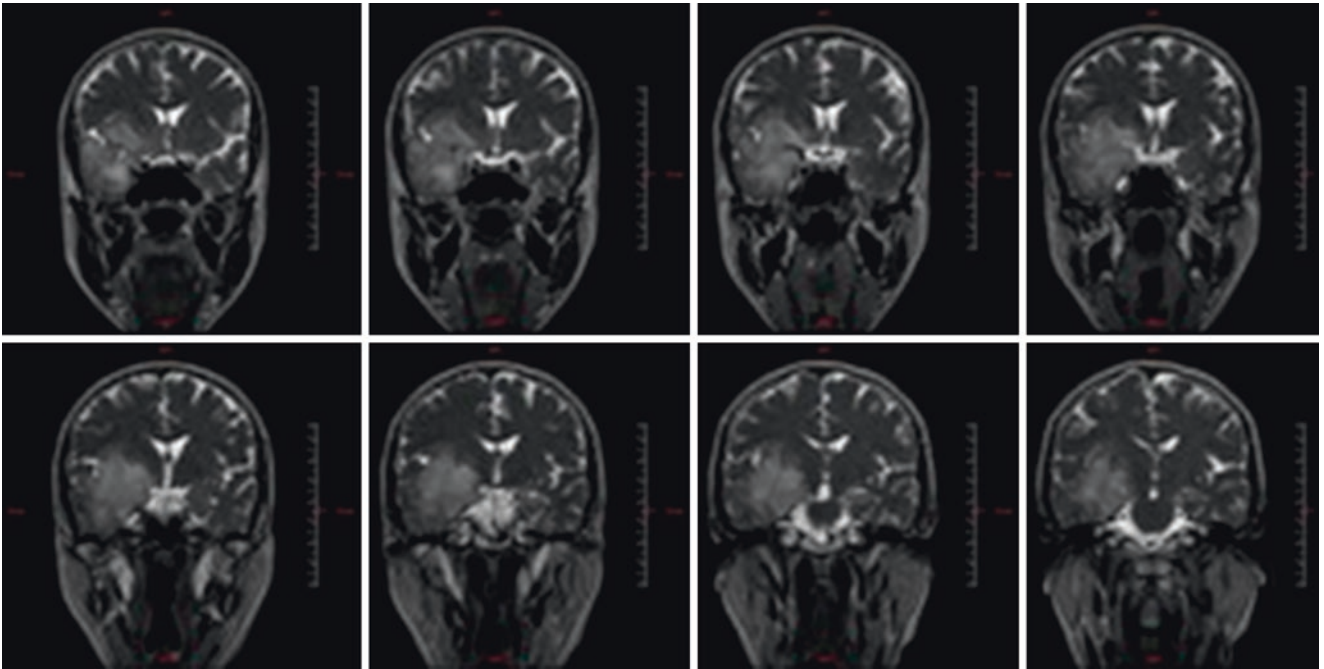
Coronal T2 MRI sections of a right insular glioma extending into both the frontal and the temporal lobes. The hippocampus is infiltrated (Yasargil type 5B)
